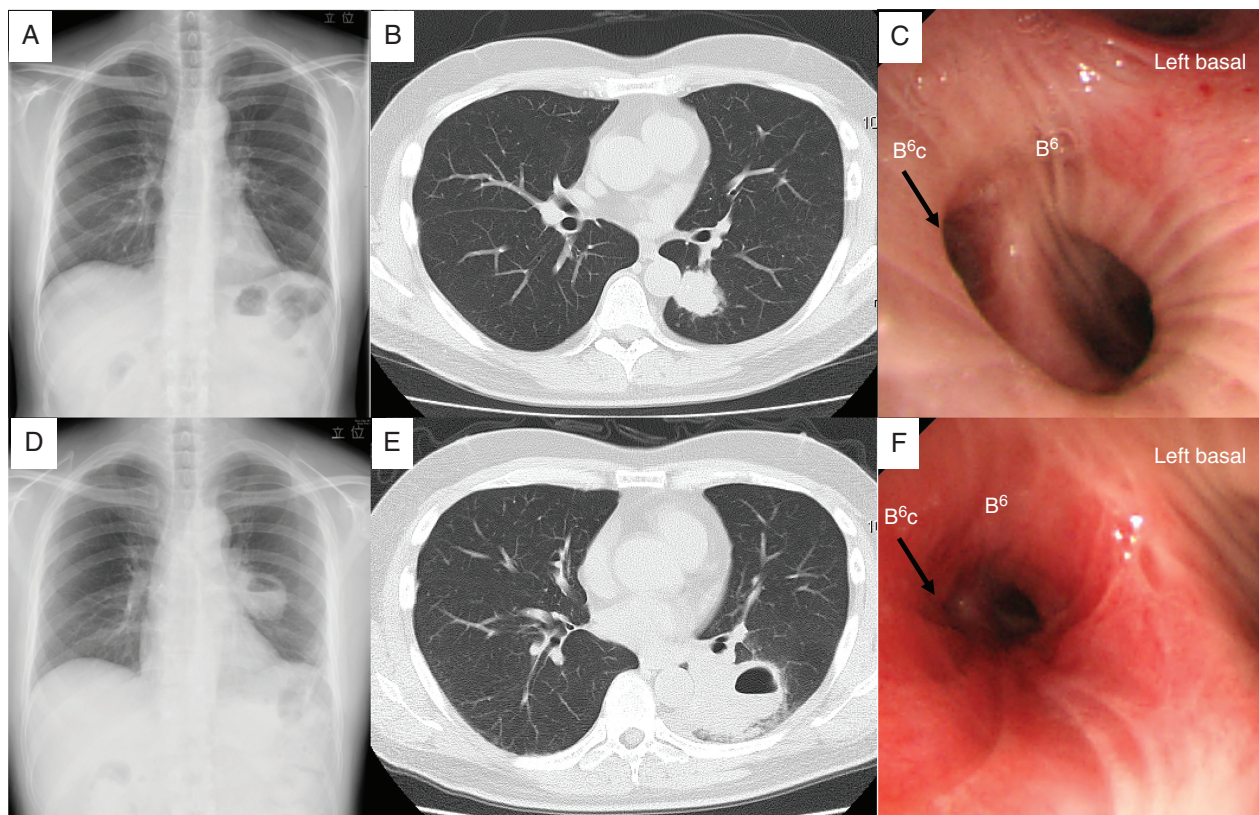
(A) Chest X-ray and (B) chest computed tomography (CT) demonstrated a nodule in the left lung at first visit. (C) Transbronchial biopsy (TBB) was performed from the left bronchus 6c (B6c). (D) Chest X-ray and (E) CT showed a nodular shadow with niveau formation around the known nodule after the transbronchial biopsy. (F) Second bronchoscopy showed that the mucosa of left B6c orifice was reddish and swelling, which resulted in severe bronchial stenosis.
